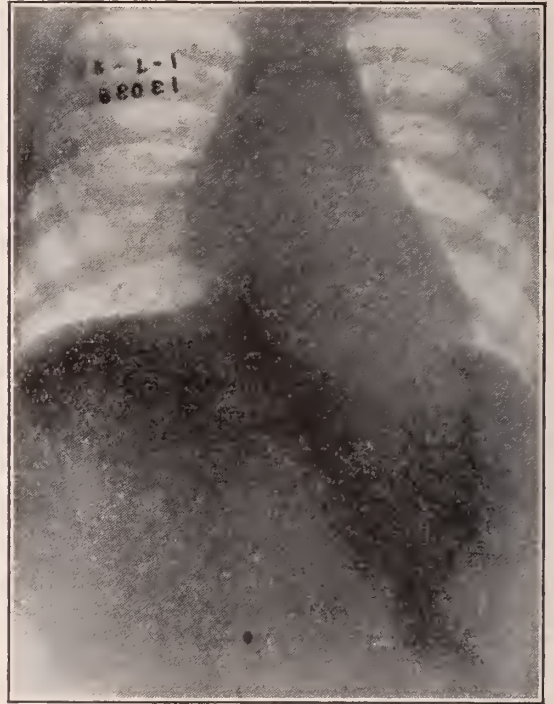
x-Ray picture of chest, large mediastinal mass.
